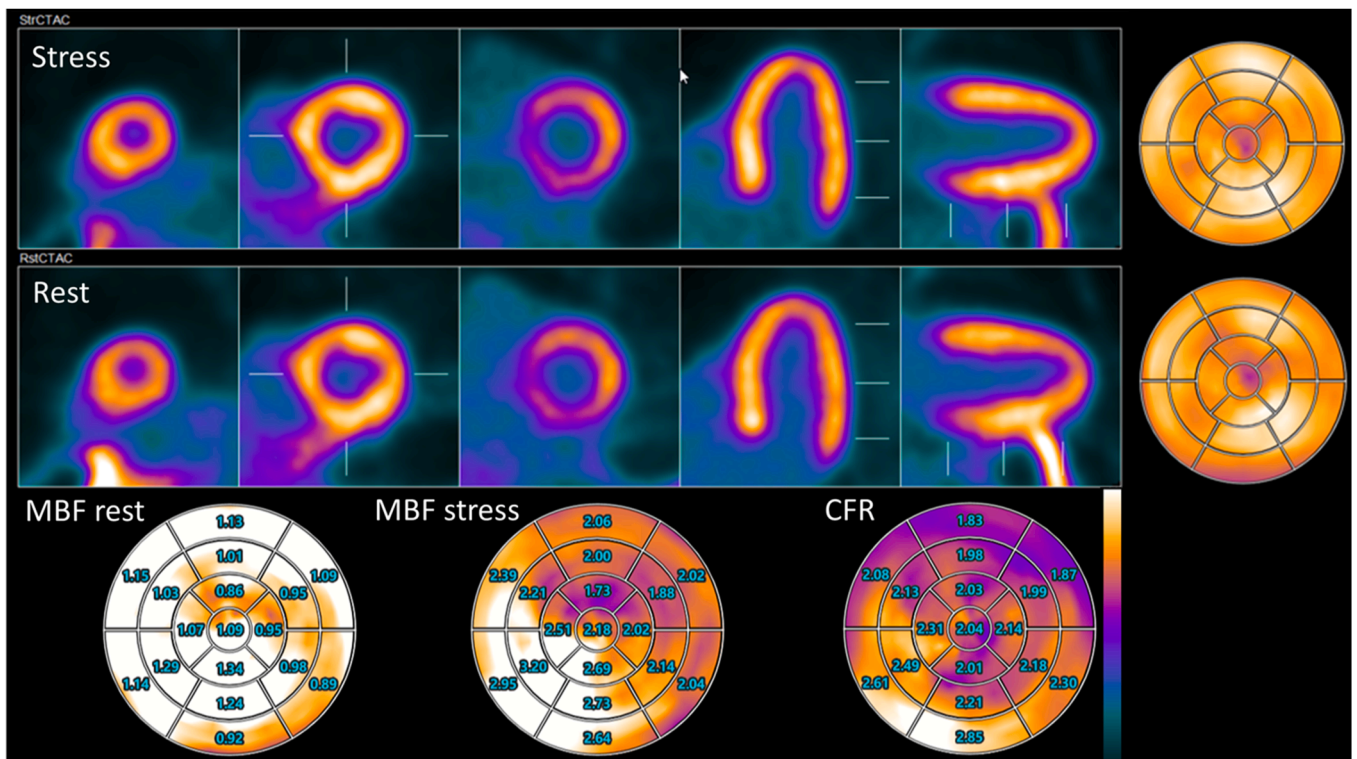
Myocardial perfusion images with ^{82}Rb and long-axial field of view PET/CT. Images were acquired using the Biograph Vision Quadra long-axial field of view PET/CT system (Siemens Healthineers) after injection of 370 MBq ^{82}Rb in a patient with chronic chest pain. Upper and middle panels show retention images and polar maps at stress and rest, respectively. Lower panels show MBF at rest and stress and myocardial flow reserve (MFR, scale bar 0-1 mL/g/min for rest, 0-2.7 mL/g/min for stress and 0-3.0 for CFR). Tracer uptake is normal and quantified MBF and CFR are within normal range. Image courtesy of Federico Caobelli, Inselspital Bern, Bern, Switzerland. MBF, myocardial blood flow; PET/CT, positron emission tomography/computed tomography.
